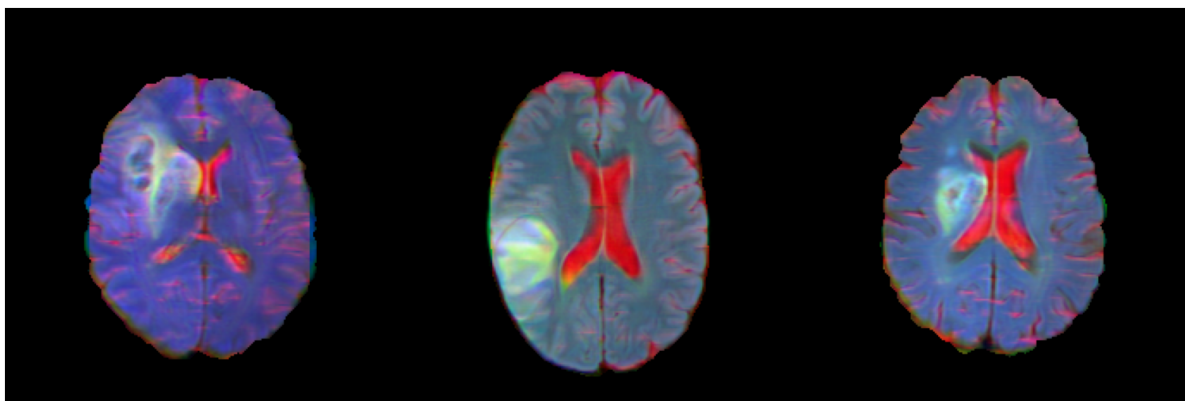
Concatenation of DWI T2 FLAIR image modalities.
